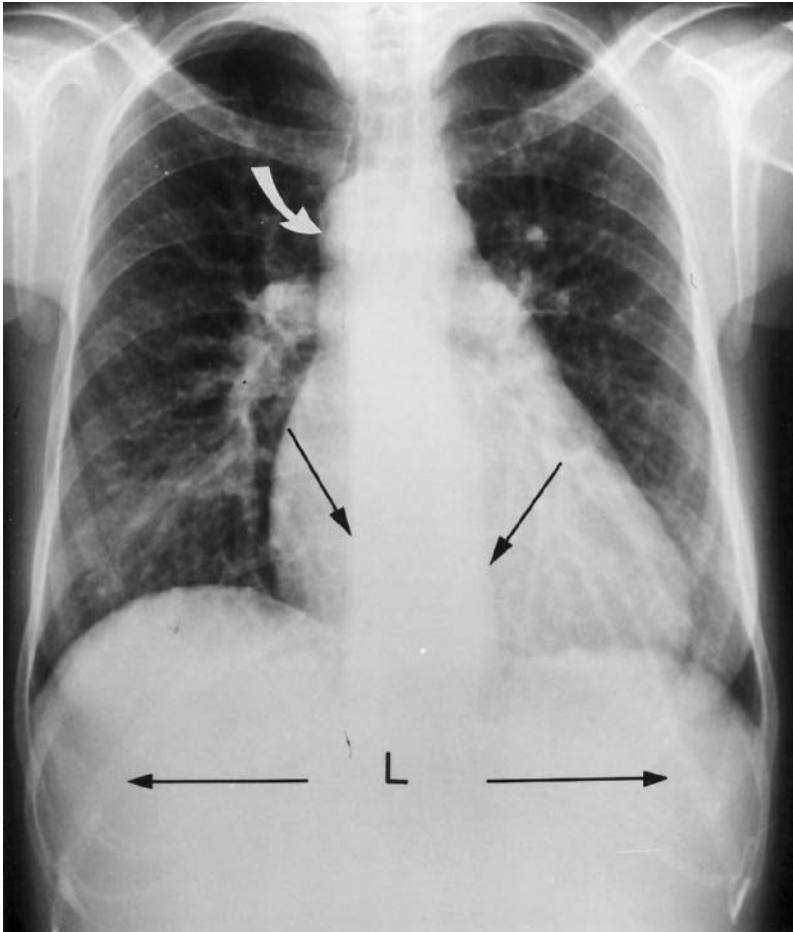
X-ray from a 29-year-old female with a transverse liver (L), left isomerism, inferior vena caval interruption, and azygos continuation that ascends along the right side of the vertebral column (oblique black arrow), forming a knuckle (curved white arrow) as it courses anterior to join the right superior vena cava. A normal left aortic arch indents the trachea on its left, and descends along the left side of the vertebral column (second oblique black arrow).
